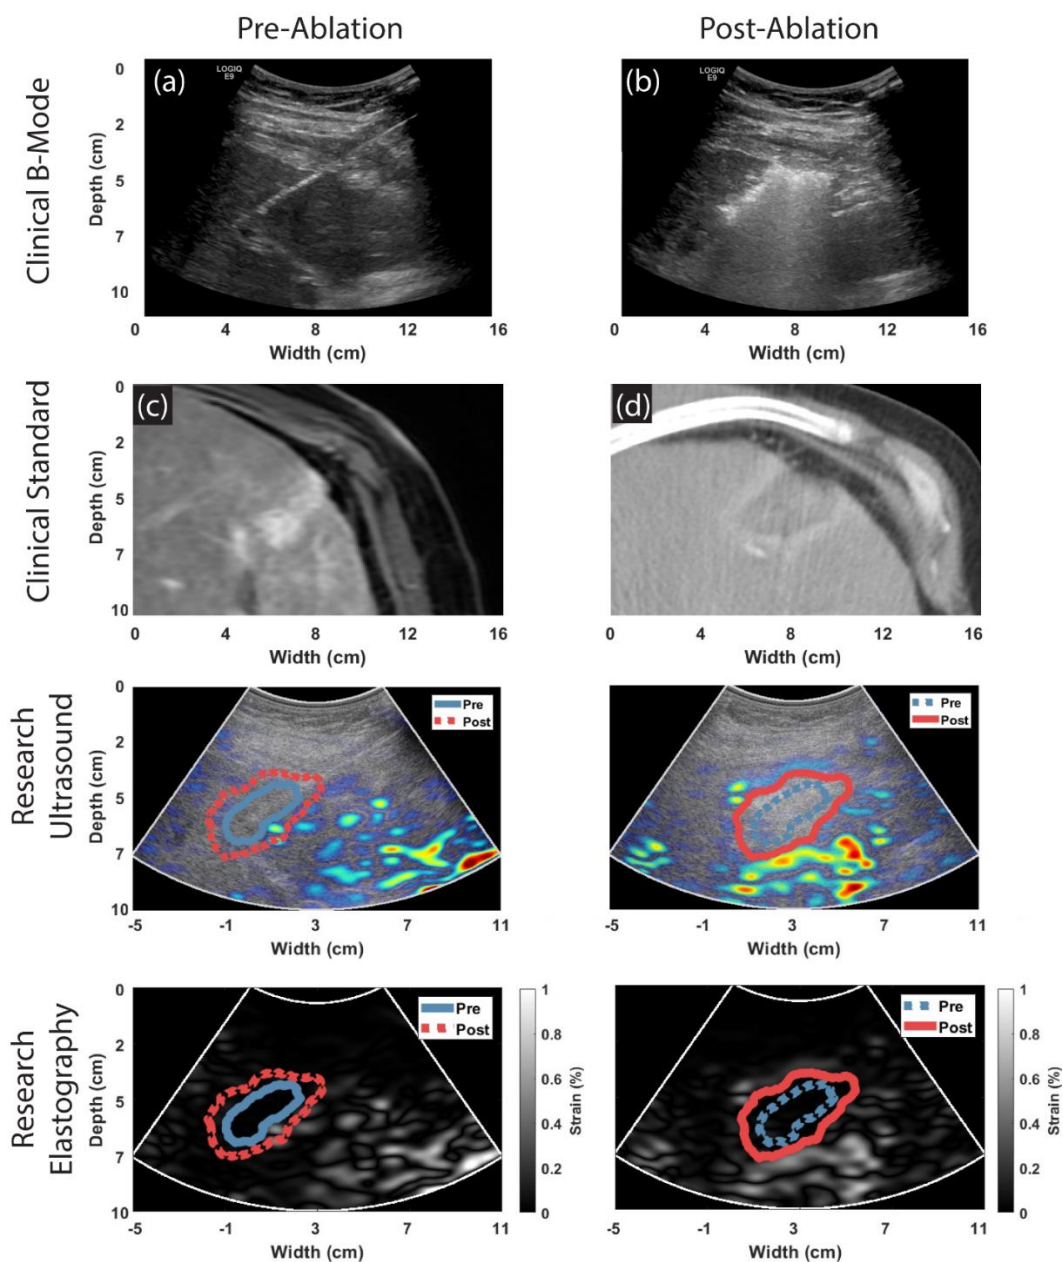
An example of differentiating pre and post ablation regions from a patient with HCC. Subfigures (a) and (b) show the clinical B-mode images of pre and post ablation respectively, (c) shows the pre-procedural MR image of the target tumor and (d) shows the CT slice complementing the planes shown in (a) and (b), (e) and (f) show the B-mode images from the frames which elastography images were estimated, while (g) and (h) show results of EDE with improved lesion visualization. Blue and red curves in (g) and (h) represent the pre-ablation tumor and post-ablation zone segmentations respectively from strain tensor images.
